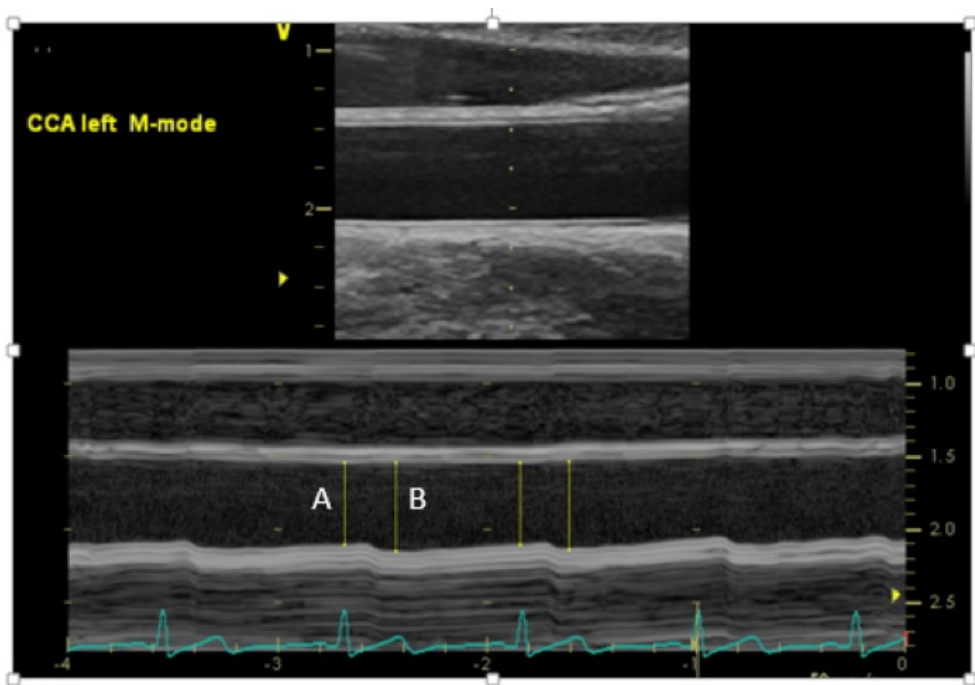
Ultrasound image obtained during measurement of carotid artery distensibility. The change in arterial diameter during diastole (A) and systole (B) related to pulse pressure is used to describe arterial distensibility. Reproduced with permission from the thesis by Mikola, (2018).
